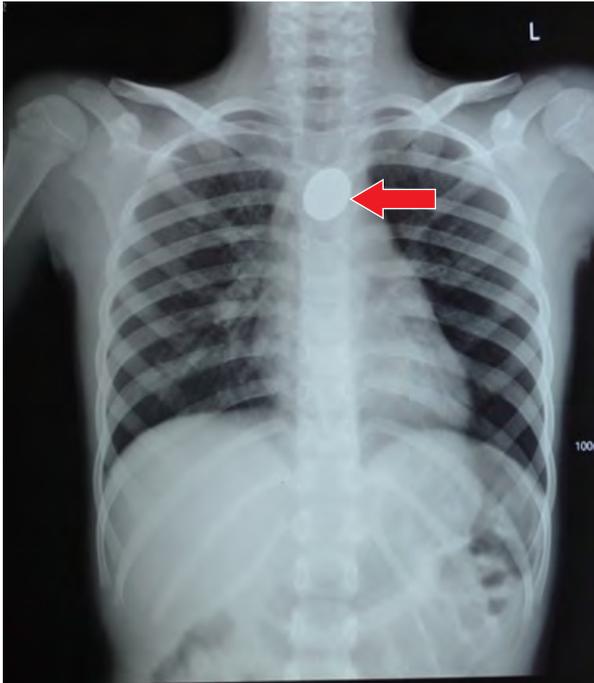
A chest X-ray showing a 20 pesewa coin just below the thoracic inlet.(arrow)
